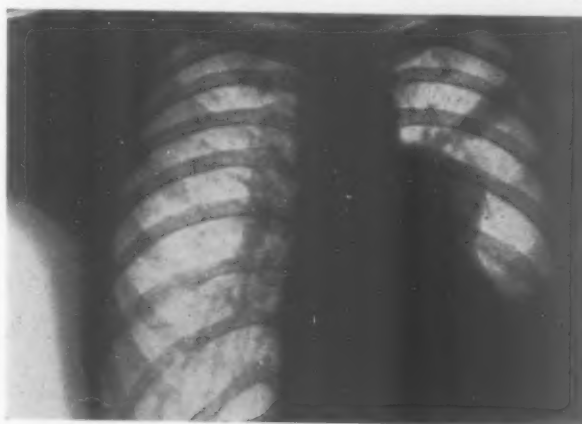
X-ray of chest taken September 18, 1924, when the tumor was first discovered.
